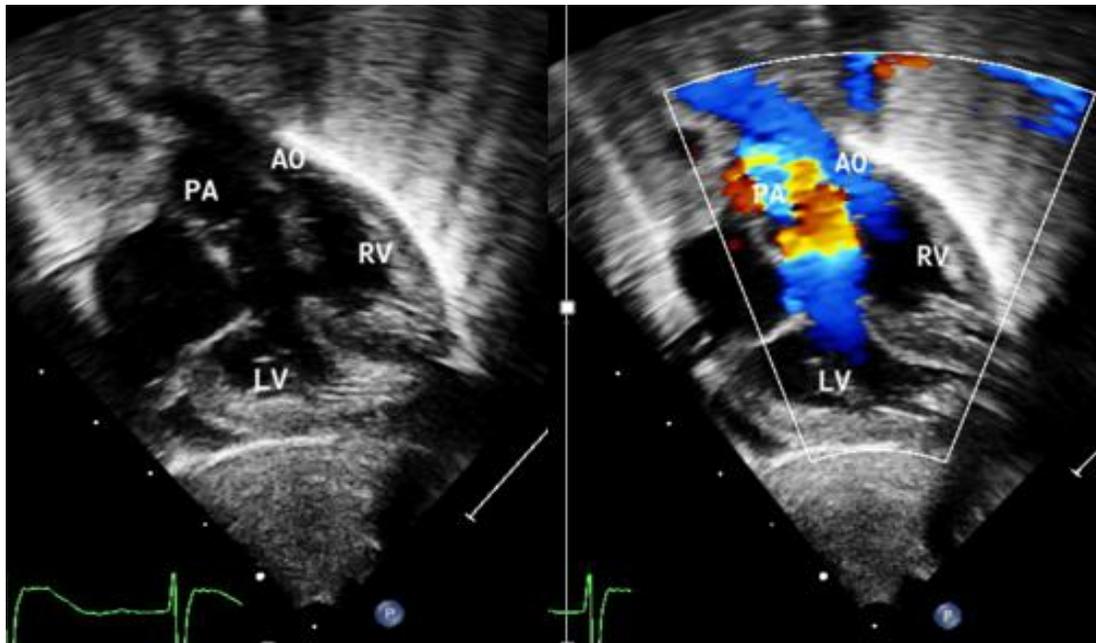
Apical four chamber views of transthoracic echo showing Ventriculoarterial discordance: pulmonary artery arising from right sided left ventricle and aorta arising from left sided right ventricle and large ventricular septal defect. (LV: left ventricle, RV: right ventricle, AO: Aorta, PA: pulmonary artery)
